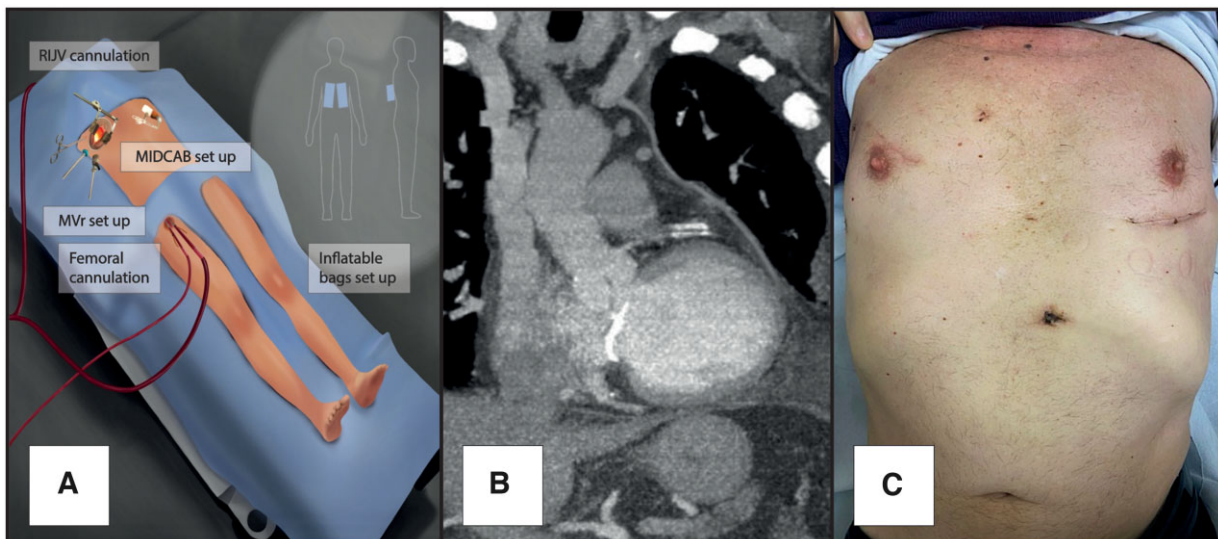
(A) Surgical set-up (bilateral mini thoracotomies, cannulation sites and inflatable bags positioning). (B) Postoperative CT scan (also showing a closed stent at the left anterior descending artery level). (C) Healing wounds.
